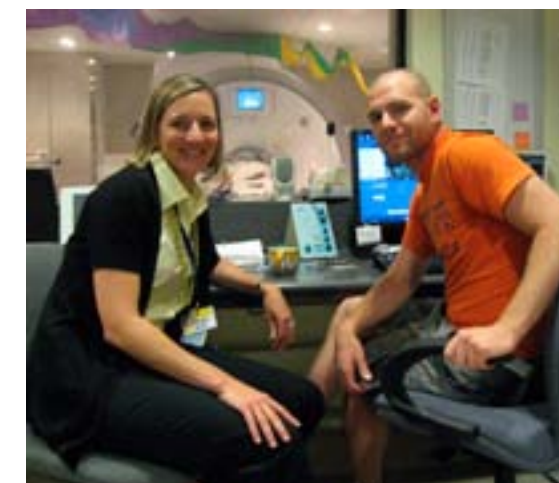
Anja Brau, PhD, GE Healthcare and Rafael O'Halloran, PhD, collaborate on high speed imaging of brain function at the 3T2 GE Healthcare '750' MRI system.
